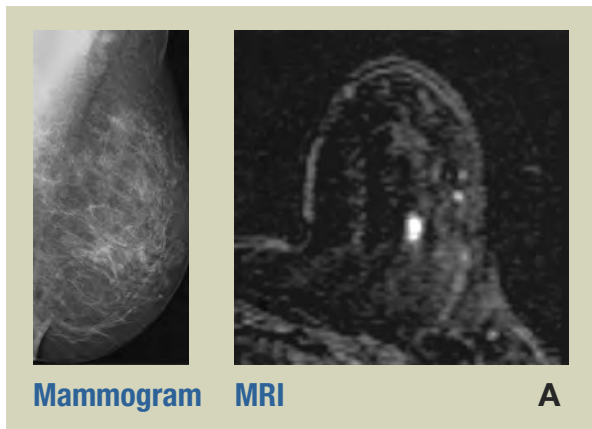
Imaging Cancer. Imaging is an increasingly essential part of modern cancer care from routine screening and prevention to informing diagnoses, and more recently to monitor response to therapy both in the clinic and during drug discovery. Not all imaging, however, provides the same quantity or type of information. For example, routine mammography (A, mammogram) detected no cancer, while MRI detected a tumor in the same breast (A, MRI)²⁰. Likewise, FDG-PET analysis reveals a bone metastasis (D, FDG-PET), whereas a CT scan detected nothing (D, CT) and MRI analysis is unclear (D, MRI)²¹. New types of imaging like FDG-PET are able to detect metastases (B, day 1) and show the patient's response to therapy (B, day 4)²². Increasingly, different types of imaging are being combined to provide the most complete information possible; the use of DC-MRI and FDG-PET (C) reveals the precise location and size of the tumor²³.
